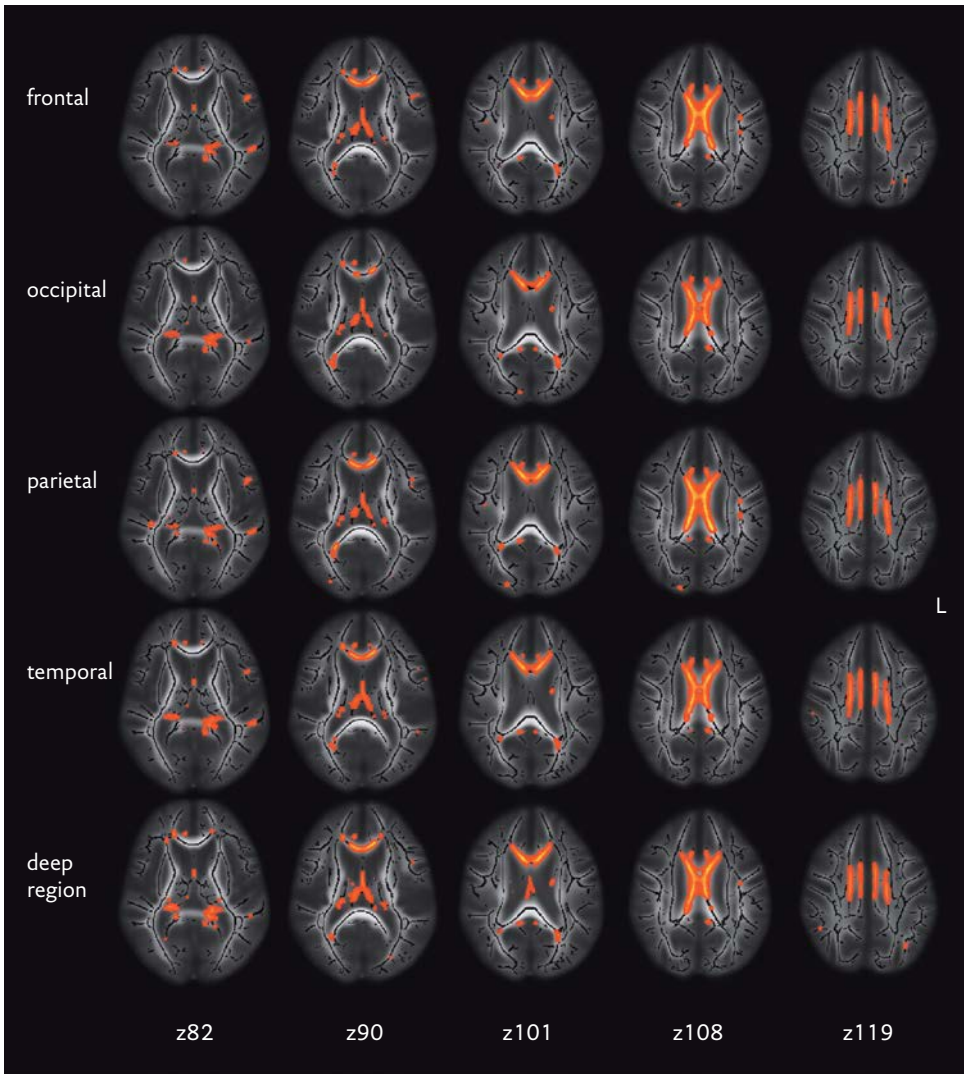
Lobar white matter atrophy and reductions in fractional anisotropy. Axial projections of mean fractional anisotropy (FA) MRI images on which the white matter skeleton (black) is projected. Images are shown in the Montreal Neurological Institute (MNI) stereotaxic space, with MNI coordinates for axial levels (z) depicted for each column. Axial levels correspond to the levels depicted in Figure 4.1.2. Yellow-to-red colors represent normal-appearing white matter regions with reduced fractional anisotropy (FA) in relation to lobar white matter atrophy (represented in rows; respectively frontal, occipital, parietal and temporal lobes and the deep region), adjusted for age, sex and relative white matter lesion volume. The regions that show significant reductions in FA associated with lobar white matter atrophy do not differ between the lobes and are furthermore similar to the regions that show FA reductions with global white matter atrophy (see Figure 4.1.2).
